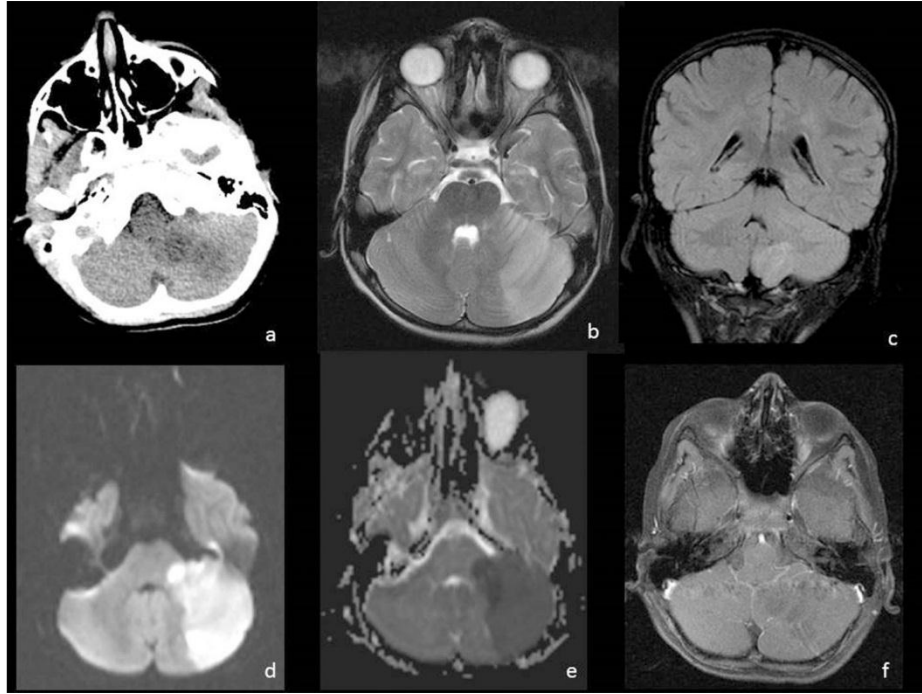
CT image (a), axial T2 (b), coronal Flair (c) MR images, diffusion b1000 (d) image, apparent diffusion coefficient map (e) and postcontrast axial T1 images obtained just a few hours later after the onset of the complaints. Hypodensity on CT image and hyperintensity on T2 and Flair images at the left cerebellary hemisphere are seen. Diffusion restriction is also seen on diffusion weighted images at the left cerebellary hemisphere and left middle cerebellary peduncle compatible with acute ischaemia. There is no enhancing after contrast administration on postcontrast image.
